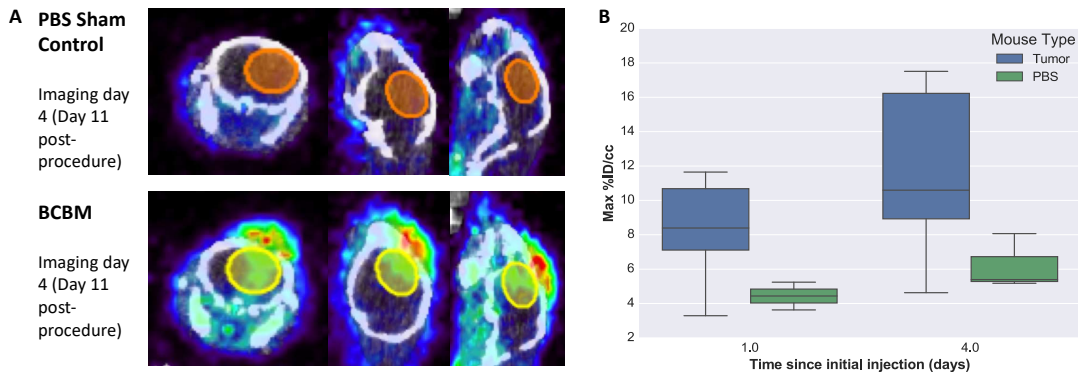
$^{18}\text{F}$  FDG uptake over the natural course of BCBM growth. A. axial, coronal, and sagittal fused PET/CT images demonstrating volumes of interest from which statistics were derived using AMIDE. Maximum injected dose per volume measured from VOIs of PET/CT images.
